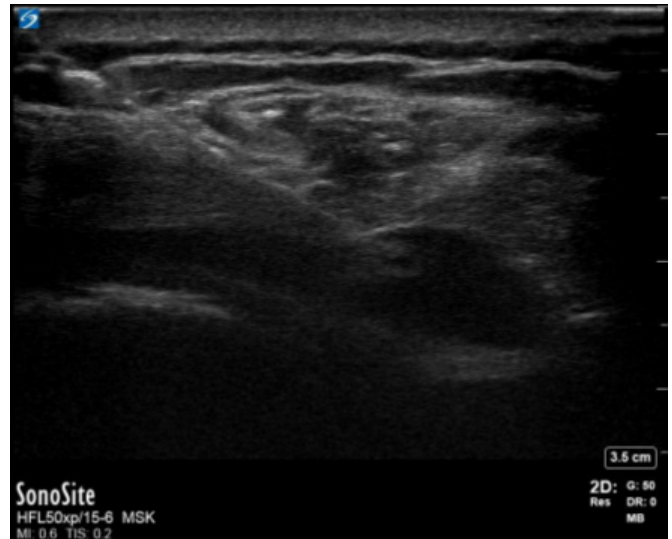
Ultrasound-guided needle aspiration of the right subdeltoid bursa. Position 4 in the Jacobson 5-position shoulder ultrasonography evaluation. The orientation of the probe was rotated 180° compared with figure 2 to facilitate in plane needle guidance.
